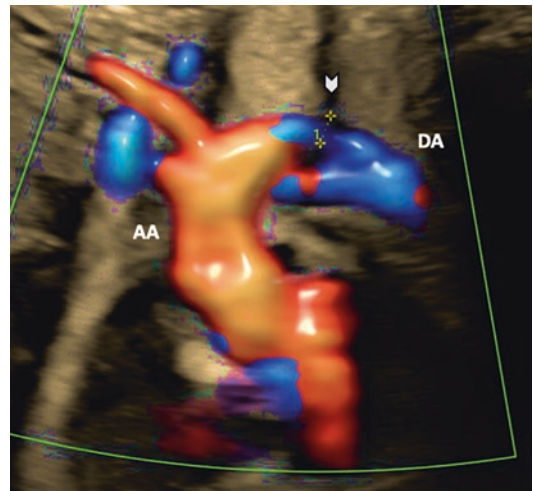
Three-dimensional visualization of two-dimensional color Doppler depiction of aortic coarctation (white arrow). Note the clarity of the image achieved by the three-dimensional appearance of the vessel with shadowing of the vessel margins and reflective highlighting by Phong filtering technique. *AA* Aortic arch, *DA* Descending thoracic aorta
